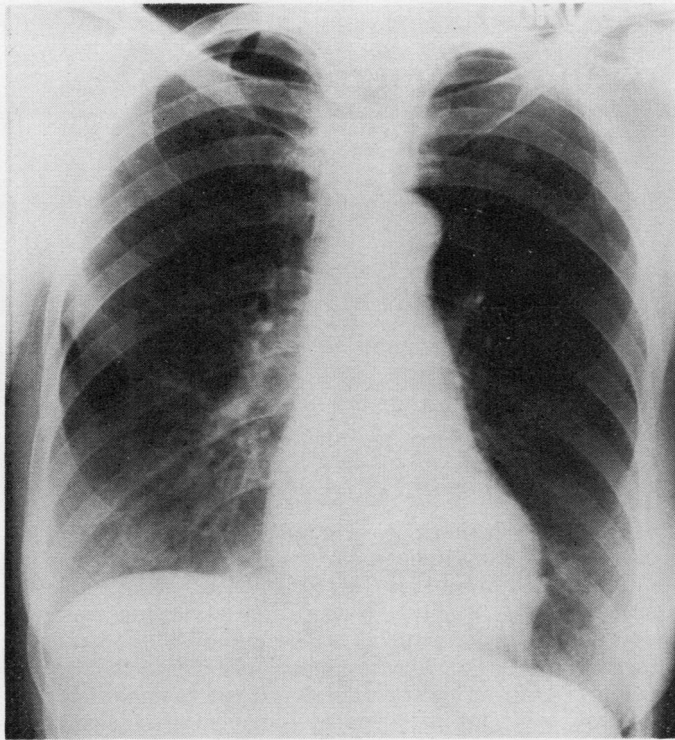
Preoperative chest radiograph showing a left upper lobe nodule.*
